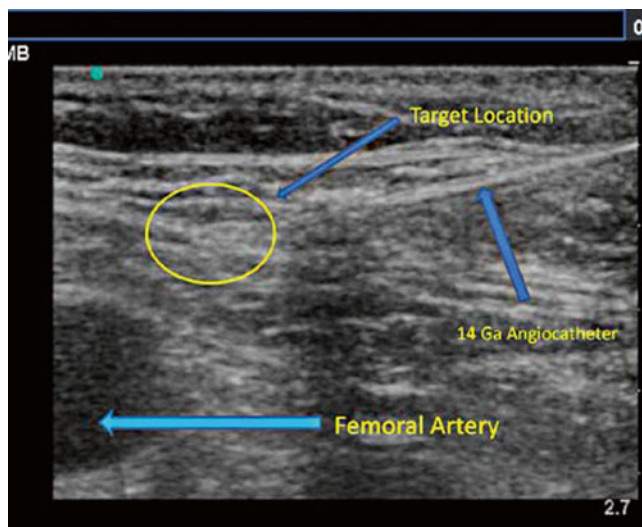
Cryoneuroablation under ultrasound of the femoral branch of the genitofemoral nerve (Image courtesy of John Chiles, MD)
